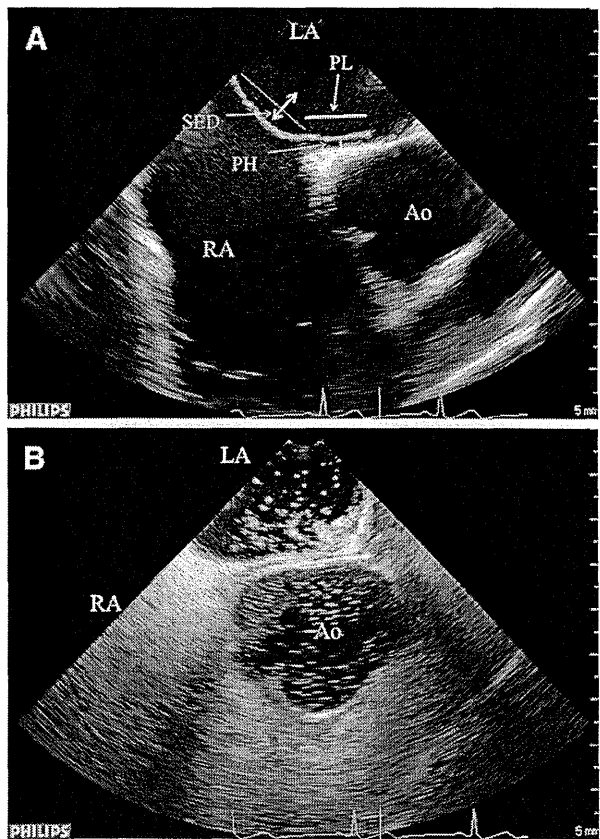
a Measurements of PFO parameters on a transesophageal echocardiogram. Transesophageal echocardiogram in the vertical plane demonstrates how the PFO was measured and evaluated. PH was measured as height of the PFO tunnel. Maximal and minimum PL was measured as overlap of the septum primum and septum secundum. SED was measured as excursion distance of the septum into the right and the left atrium. b Bubble contrast image at rest on a transesophageal echocardiogram. Contrast agent demonstrates a shunt from the right atrium to the left atrium. Ao indicates aorta, LA left atrium, RA right atrium, PL PFO length, PH PFO height, SED septal excursion distance
